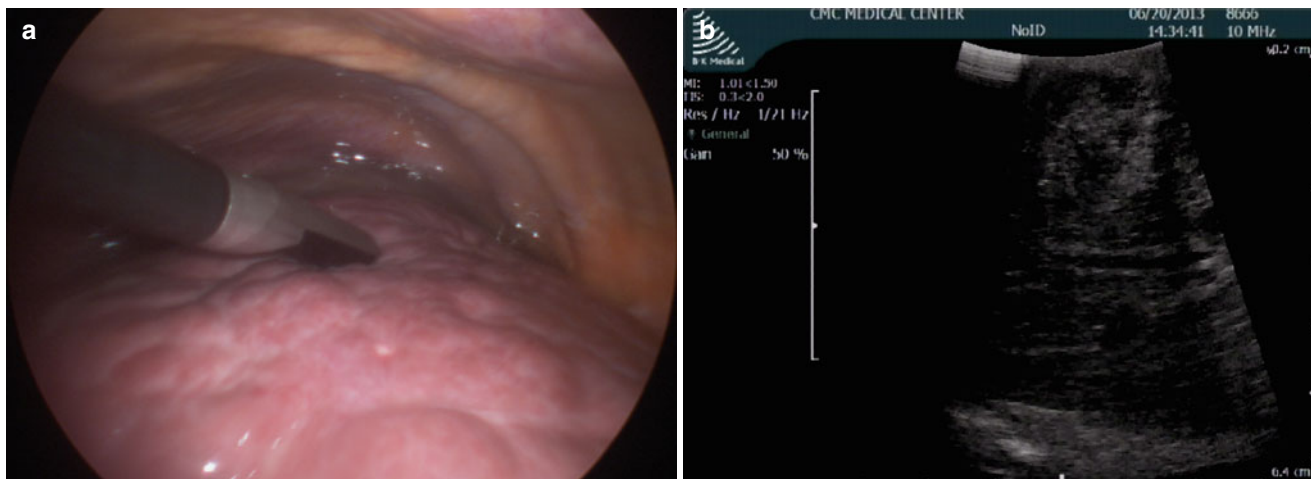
(a) Intraoperative image of ultrasound toe touching the tissue. (b) A corresponding ultrasound image showing half of field with visible tissue, orienting the toe of the probe to the right of the screen
